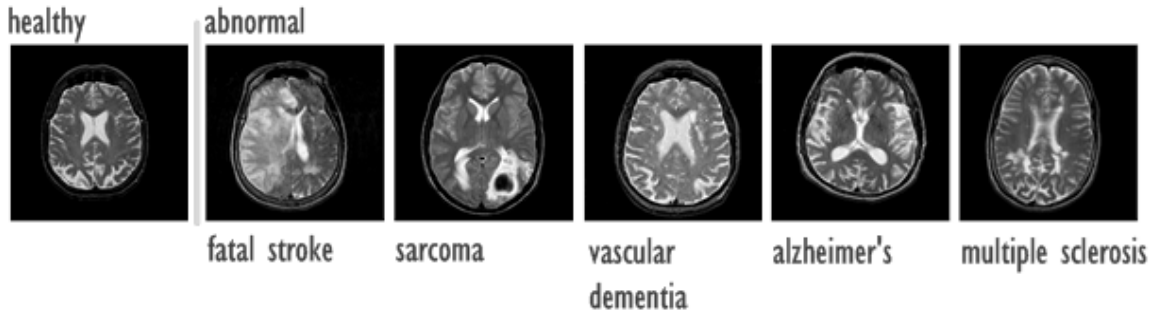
Samples of various brain MRI images.
